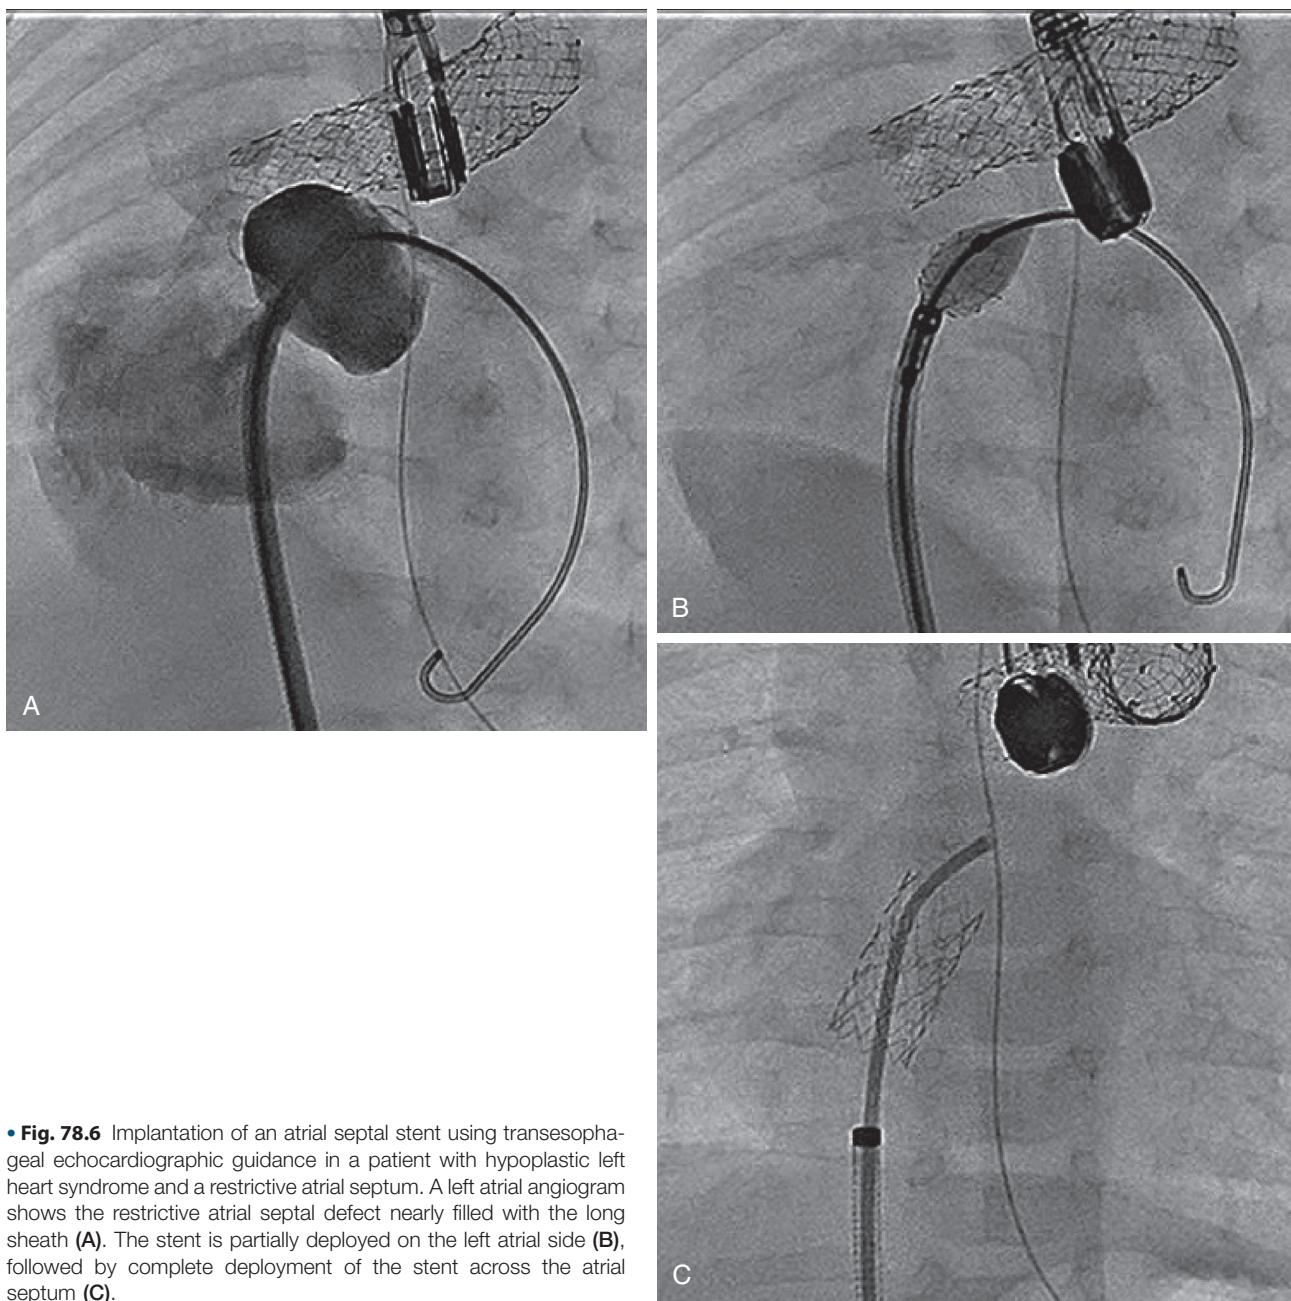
Implantation of an atrial septal stent using transesophageal echocardiographic guidance in a patient with hypoplastic left heart syndrome and a restrictive atrial septum. A left atrial angiogram shows the restrictive atrial septal defect nearly filled with the long sheath (A). The stent is partially deployed on the left atrial side (B), followed by complete deployment of the stent across the atrial septum (C).
